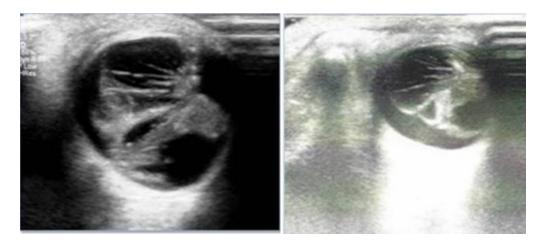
Ocular doppler echography of the left eye disclosed multiple tubular stalks of fibrovascular tissue attached to the posterior surface of the lens connecting to the optic nerve with blood flow inside the stalk vessels.
